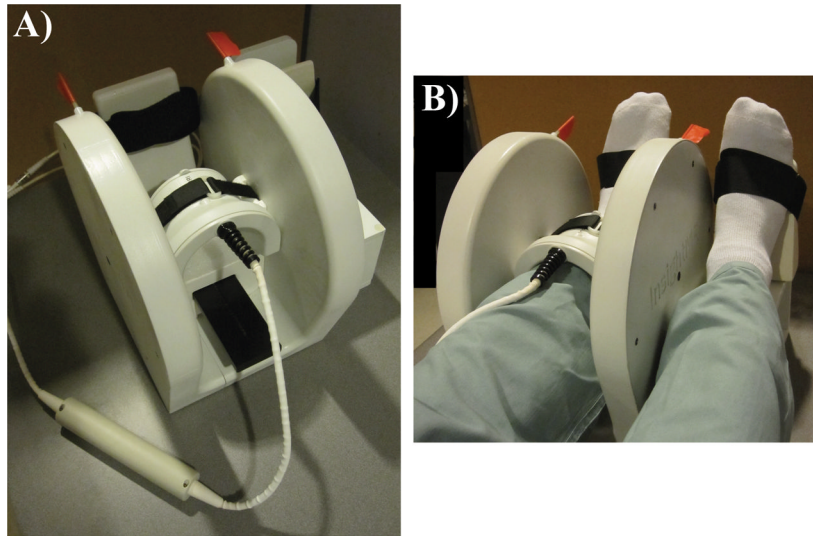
Imaging setup consisting of (A) a decoupled 4-element phased array receive coil (297.2 MHz) centered within the shielded Helmholtz pair transmit (Tx) coil (Insight MRI, Worcester, MA). (B) The configuration is shown for imaging a subject's left distal tibia with the right foot positioned on an adjacent platform (outside the Tx coil) of equal height.
